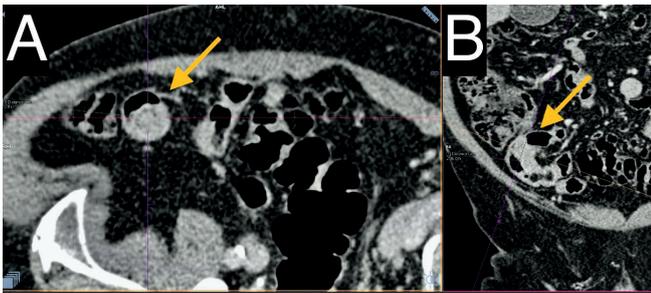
Computed tomography images showing intussusception: (A) transverse cross-section displaying the target sign in the early stage, without bowel wall edema; (B) longitudinal cross-section
